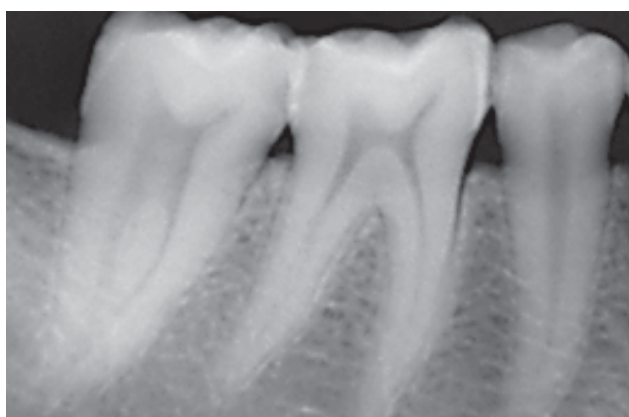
Radiograph of contralateral tooth
